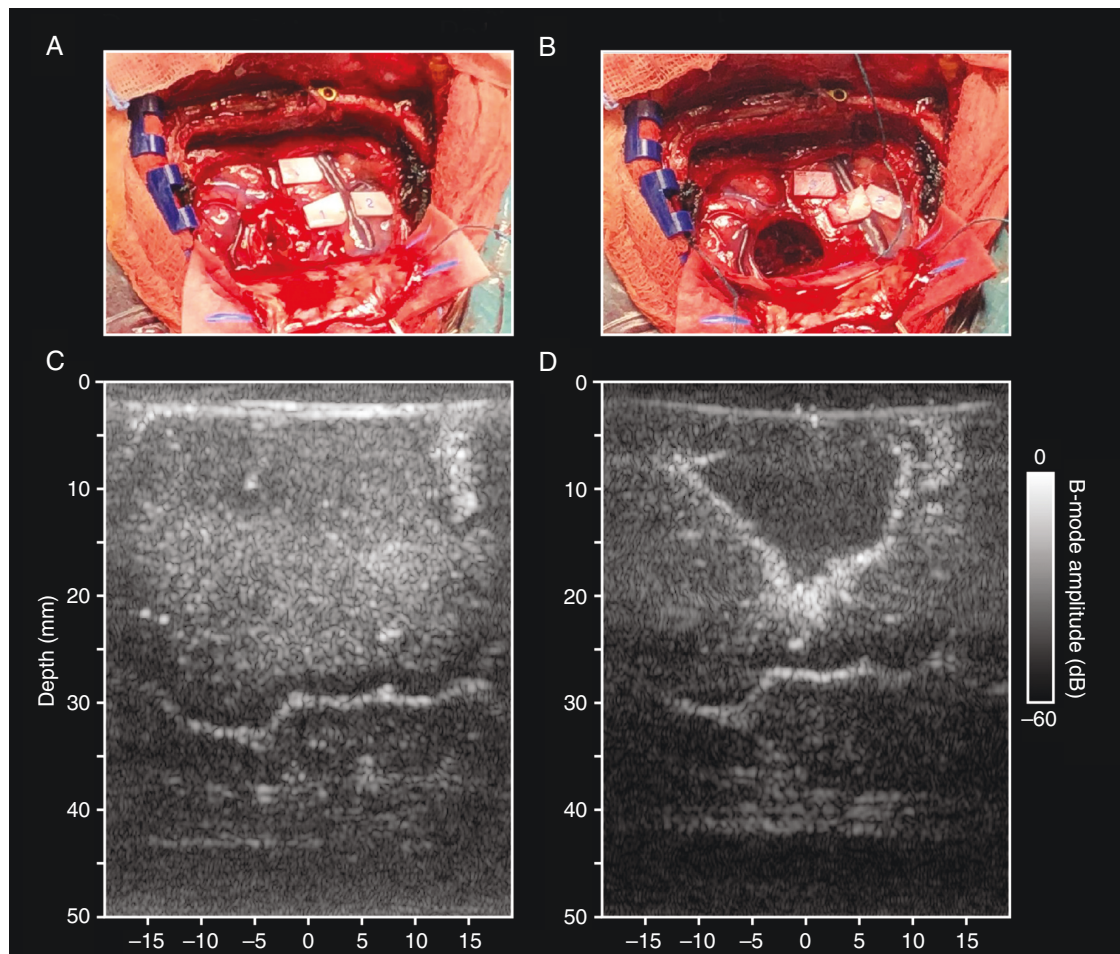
Intraoperative ultrasound. A: Intraoperative image of a glioma in the right parietal lobe. B: Intraoperative image of the cavity after tumor resection. C: Pre-resection B-mode image of the tumor and surrounding tissue. D: Post-resection B-mode ultrasound image of the resection cavity.
